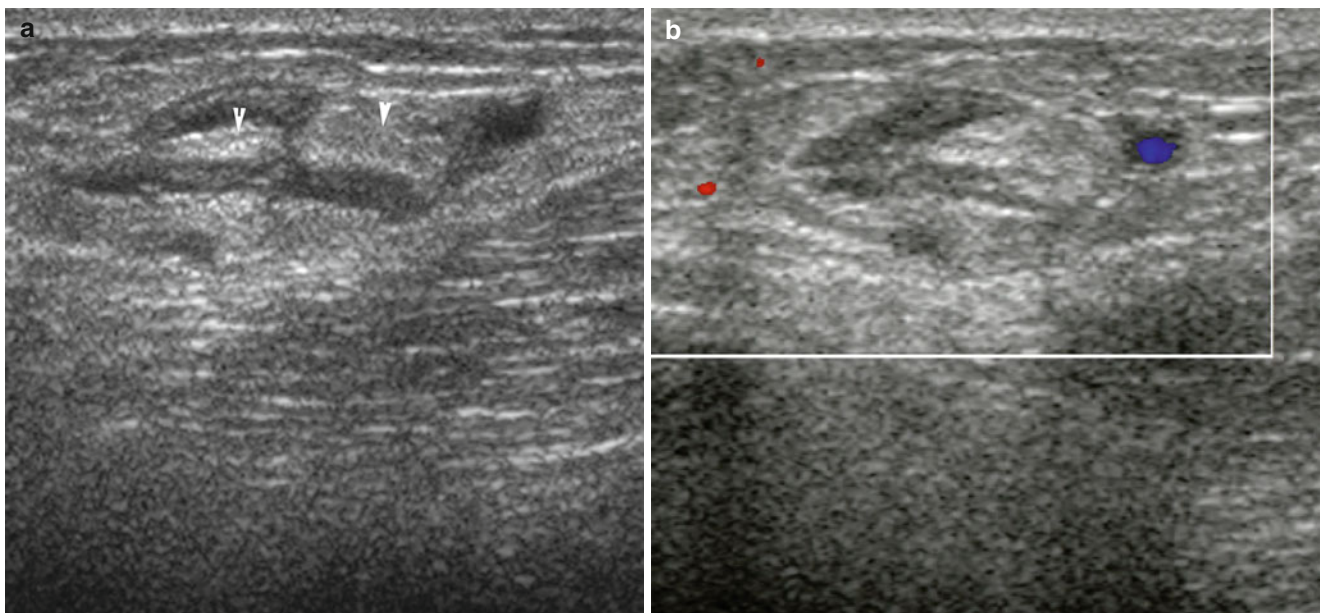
A 27-year-old female patient complaining of painful nodule over RT upper lower leg that gradually enlarged within 2 weeks. (a) Grey scale ultrasound image showing heterogeneous echogenic nodule
